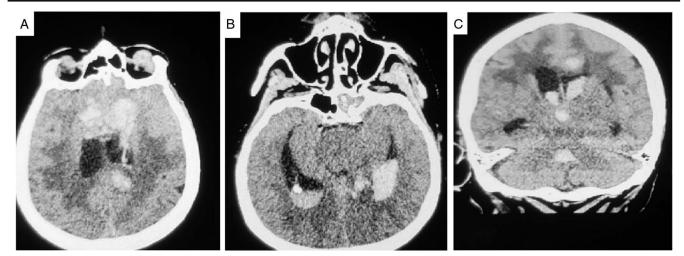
A noncontrasted CT scan of the brain, A, B. axial views, C. sagittal view and they demonstrate foci of ICH, increase of IVH along with posterior vasogenic edema.
